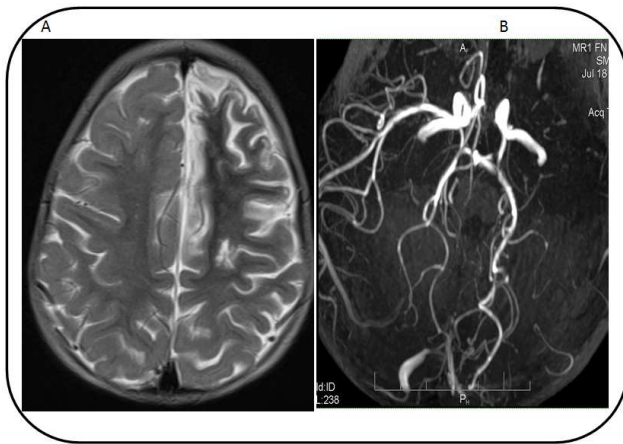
Brain MR imaging(A: Left side acute ischemic strokeB: Brain angiography:cerebral arteries stenosis).
